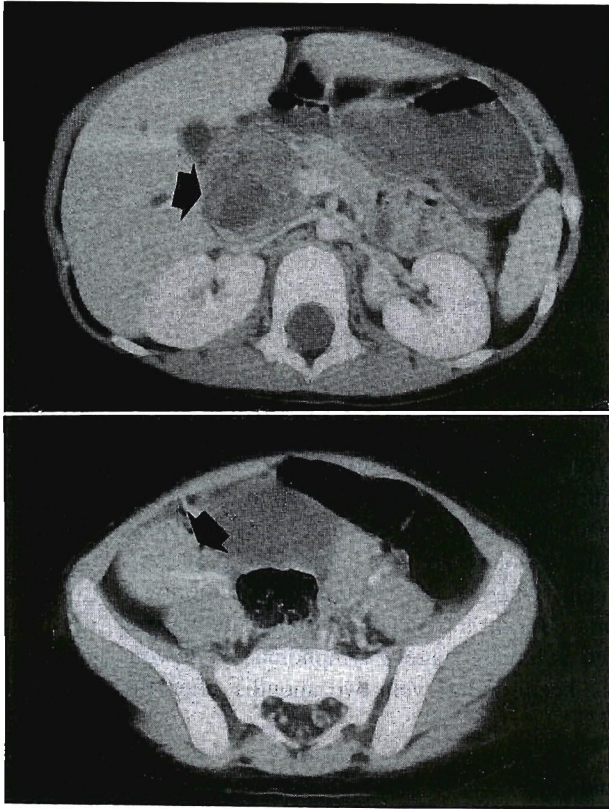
An enhanced abdominal CT scan showing a hypodensity mass in the porta hepatis (top; arrow) and a hyperdensity tumor in the pelvic cavity (bottom; arrow).
